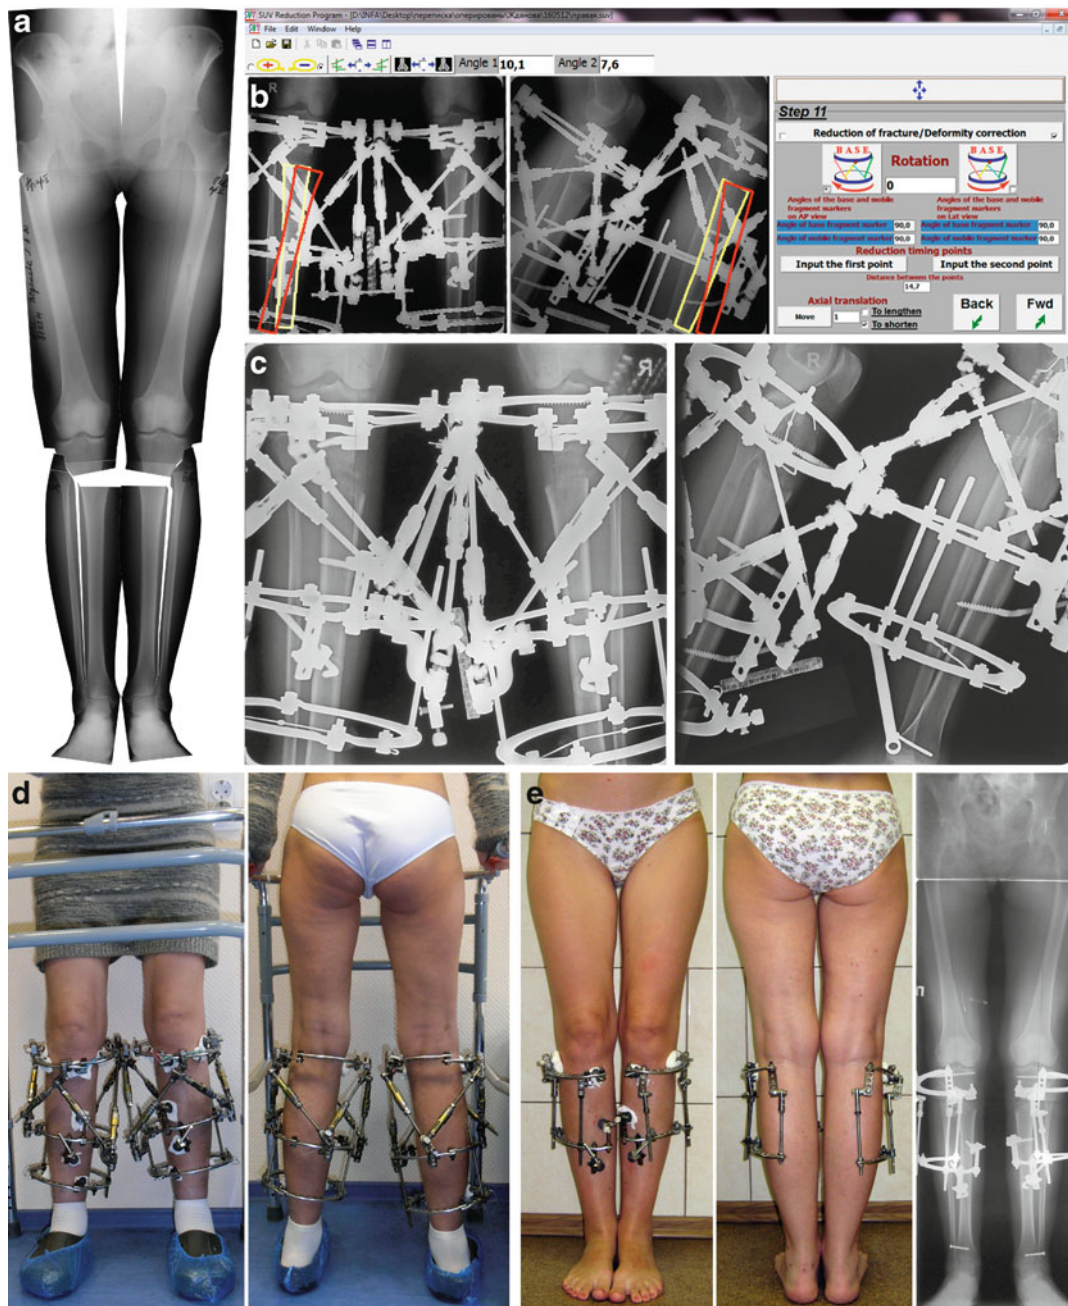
(a) Preoperative planning. To achieve the desired result, we planned to carry out lengthening of the tibia of 2 cm, medialization of the distal part of the tibia of 10 mm, and valgization of 7°. (b) The Ortho-SUV software window at step 11: the deformities correction planning. The yellow bone contour indicated the initial mobile (corresponding) fragment position. The red bone contour created by the software indicates the final position of the mobile bone fragment. The same calculation was done for the left lower leg. (c) Radiographs after correction by Ortho-SUV. (d) Photos after correction. (e) Photos and radiographs after the modular transformation. Removing of internal half rings and struts provided the opportunity for the patient to stand with legs together which is a more accurate indication of final appearance
